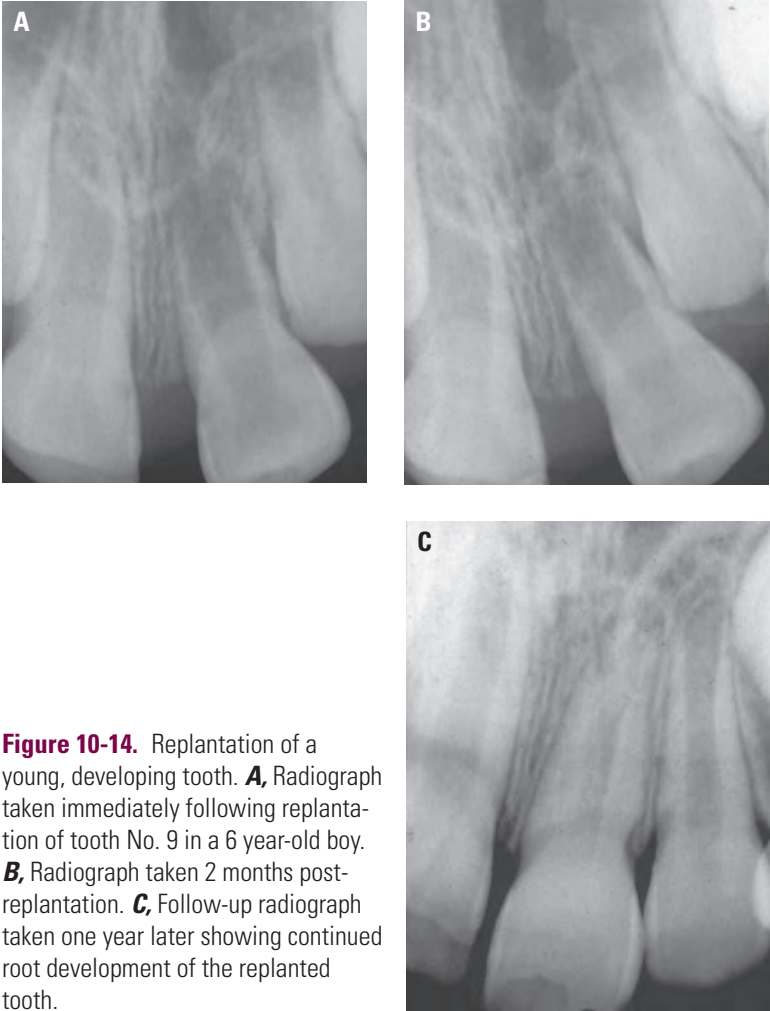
Replantation of a young, developing tooth. A, Radiograph taken immediately following replantation of tooth No. 9 in a 6 year-old boy. B, Radiograph taken 2 months post-replantation. C, Follow-up radiograph taken one year later showing continued root development of the replanted tooth.
